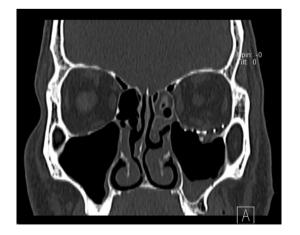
Post-op CT coronal section showing reduced orbital contents and orbital implant
